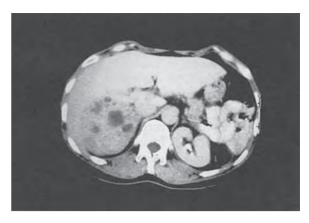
CT scan of malignant phaeochromocytoma in the right adrenal gland. Typical heterogeneous appearance with areas of haemorrhage.
